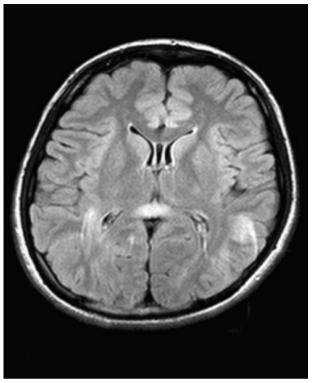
Brain MRI performed on the nineteenth day after admission (19 days after cessation of LEV), revealing an isolated oval-shaped abnormal signal on a mid-portion of the SCC with high intensity on T2-weighted imaging (T2WI) and fluid-attenuated inversion recovery (FLAIR).
